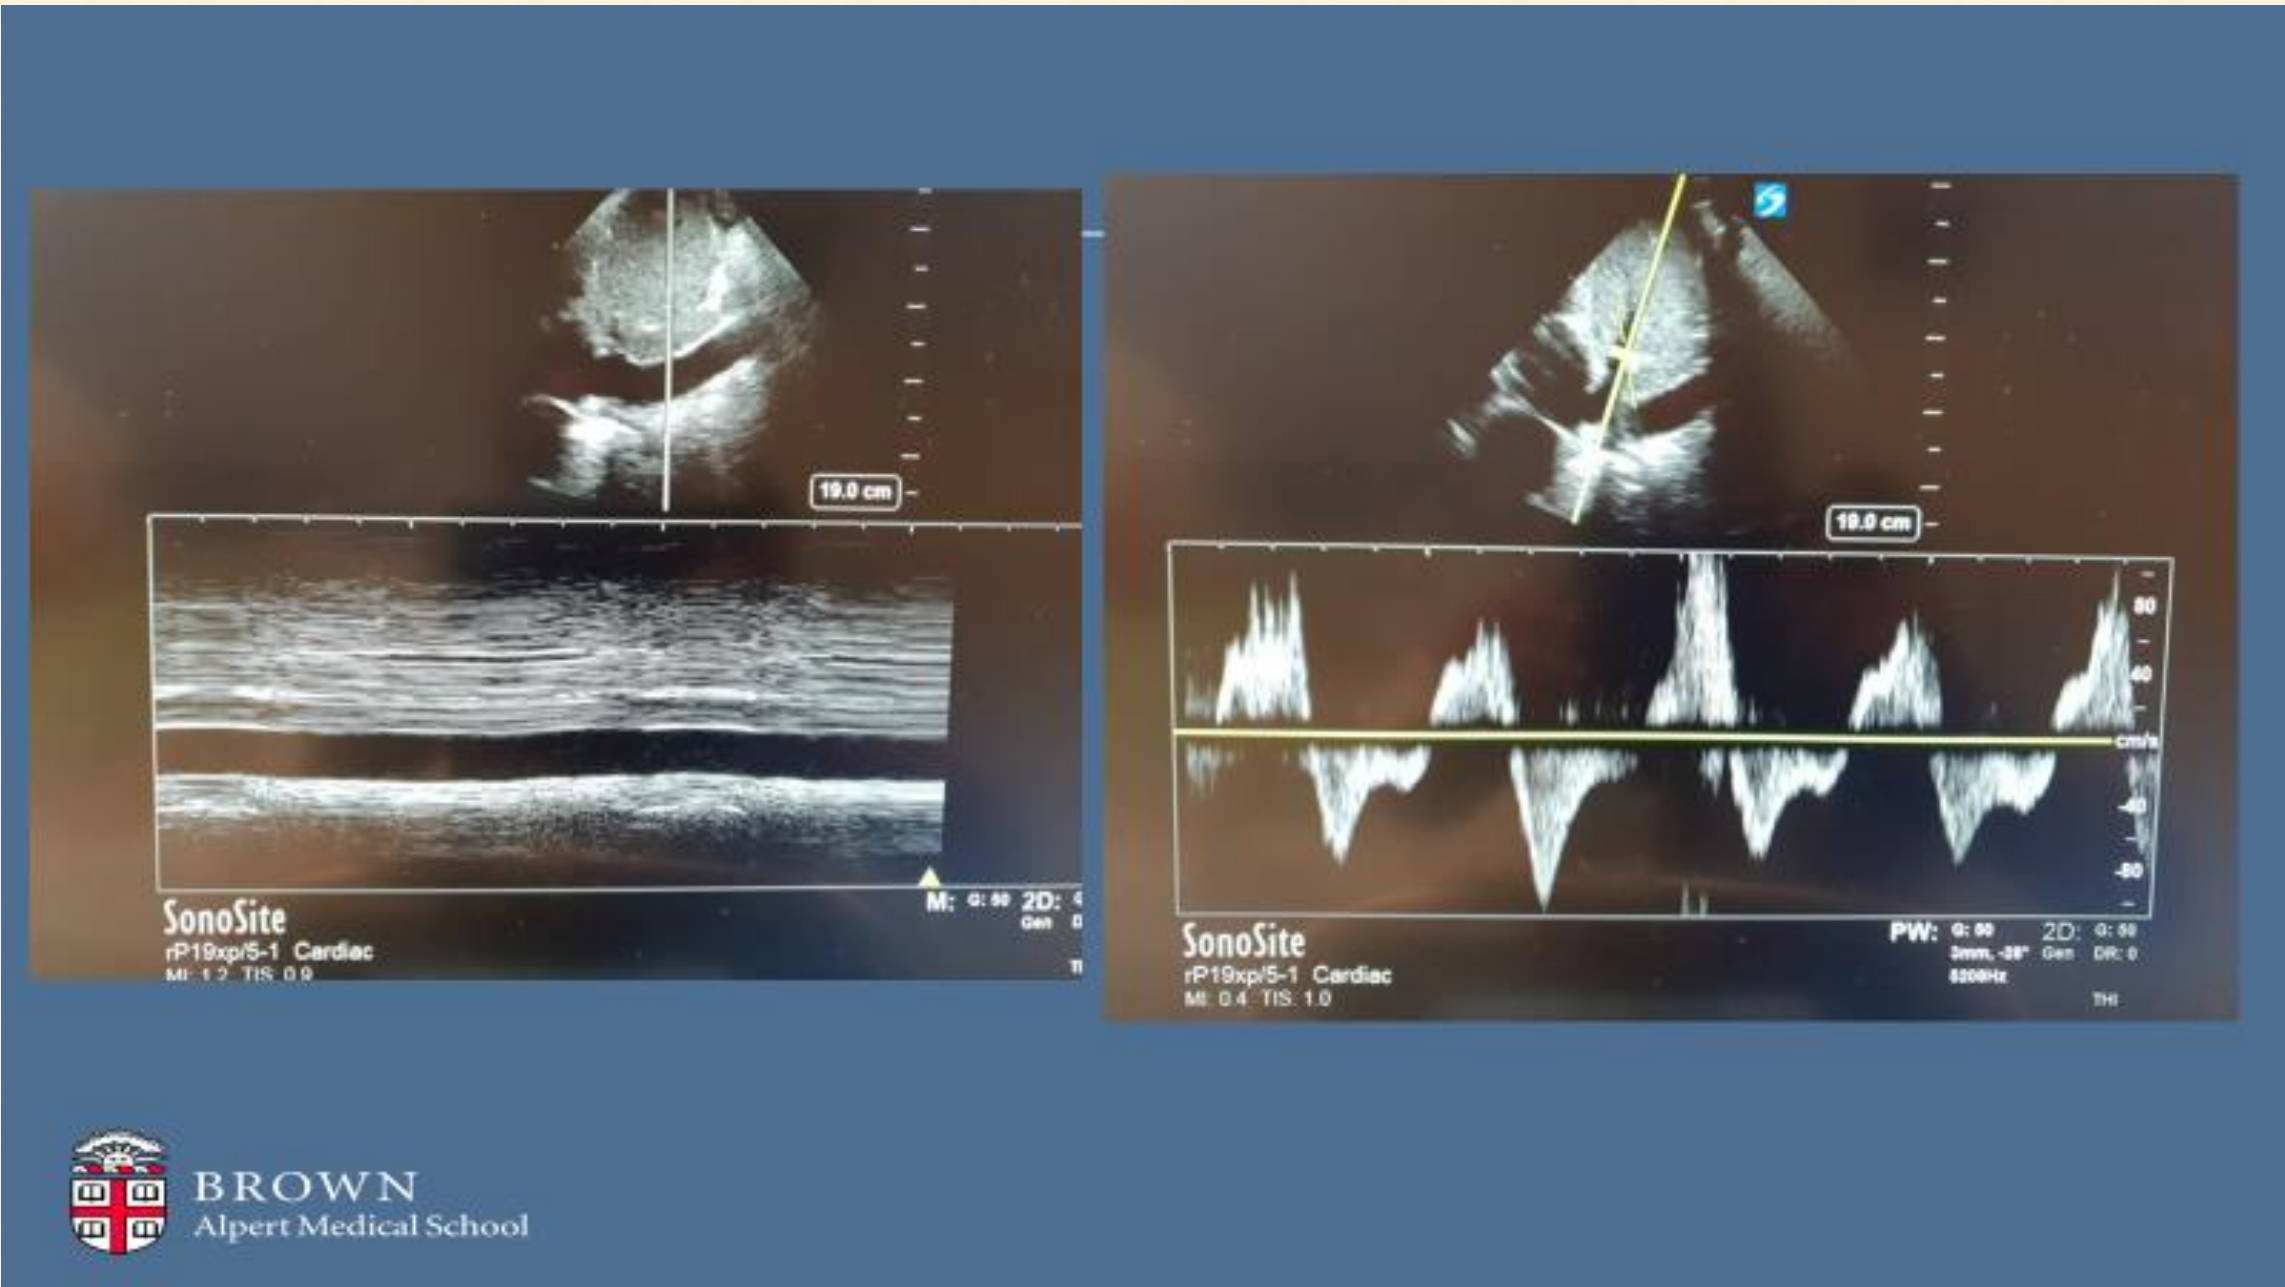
Slide demonstrating IVC ultrasound and hepatic vein doppler
